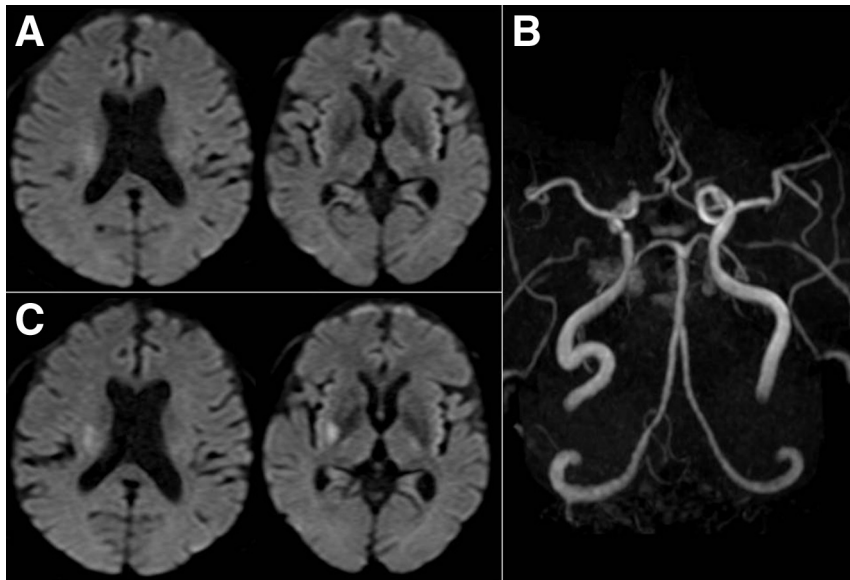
(A) Diffusion-weighted imaging (DWI, b value = 1000 s/mm^2) and (B) magnetic resonance angiography performed immediately after the fourth transient ischemic attack (TIA) show slightly hyperintense lesions in the right corona radiata and a stenotic lesion in the intracranial right internal carotid artery but no occlusion in the right middle cerebral artery, respectively. DWI 13 hours after the initial TIA, immediately after the seventh TIA, reveals an acute infarct in the right putamen expanding to the corona radiata (C).
